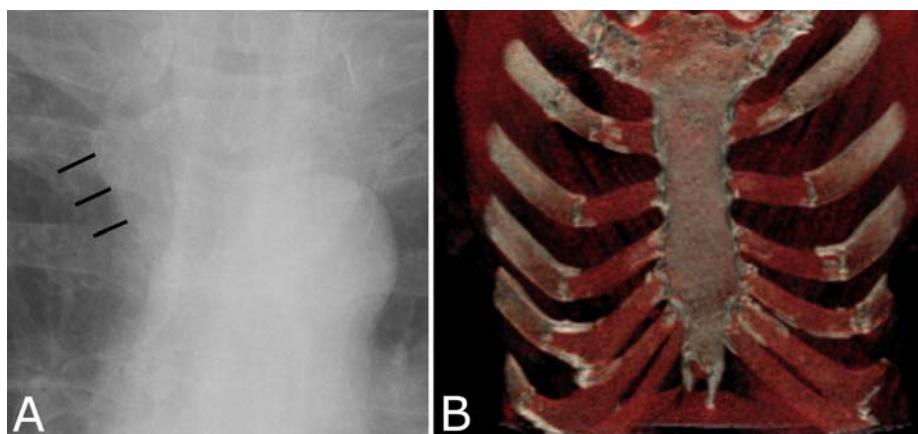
A. Frontal radiograph showing that only part of the manubrium (black lines) is well seen. B. Volume rendered CT image of the sternum showing the sternum in the same configuration that it is in on a frontal radiograph. The red areas represent the cartilage joining the anterior ribs to the sternum. This cartilage will be visible to different degrees in different patients depending upon the degree of calcification within the cartilage.
